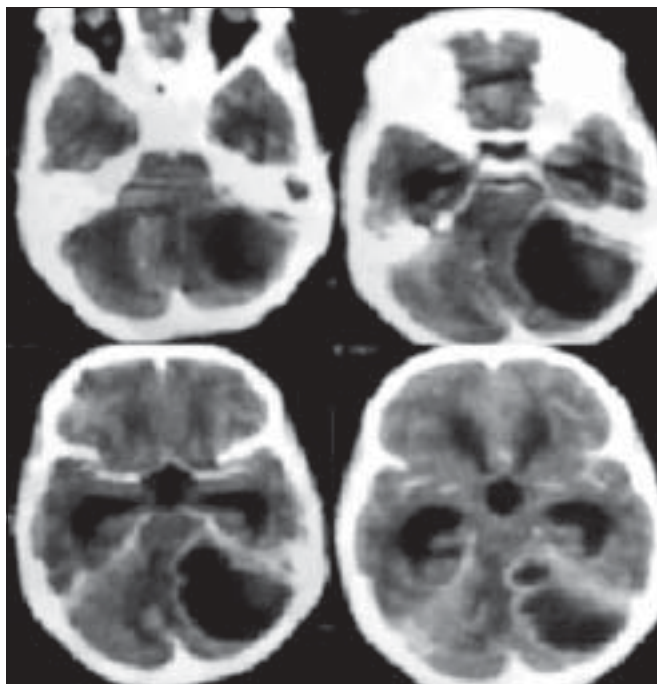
Pre-operative CT scan showing left cerebellar abscess with hydrocephalus
